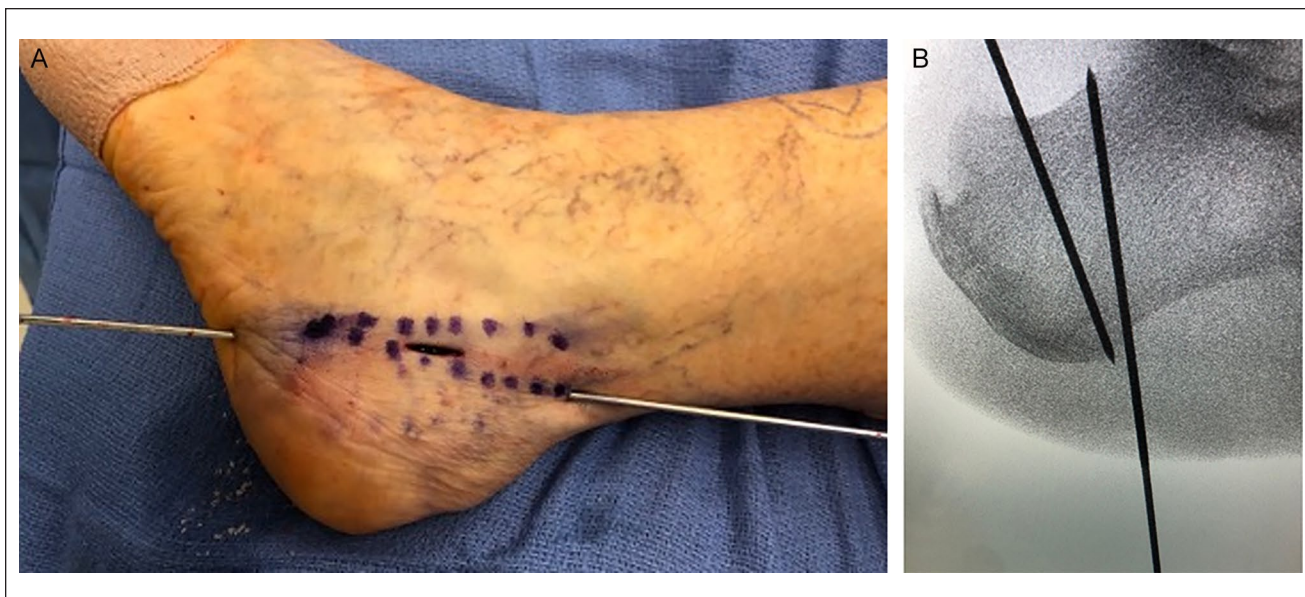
(A) Clinical photograph showing position of percutaneous K-wires acting as a cut guide for the Zadek osteotomy. (B) Radiograph image of the K-wire placement acting as a cut guide for the Zadek osteotomy.
